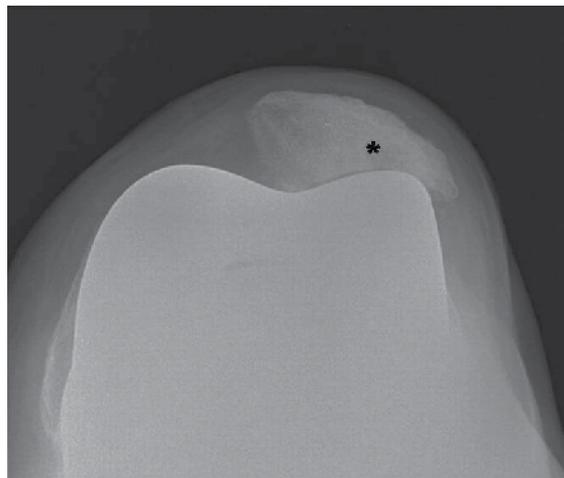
Patellar Impingement. A 71-year-old man, four years after total knee replacement. Axial radiograph (Merchant view) shows a reduction in the space between the knee arthroplasty and the patella, with consequent reactive patellar sclerosis (asterisk).
